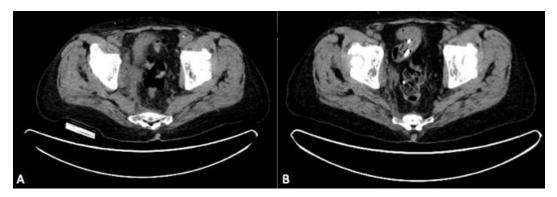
A: Initial PET/CT showing the pelvic sidewall mass measuring approximately 6.5 cm B: Restaging PET/CT showing a significant decrease in size and SUV activity in the right pelvic sidewall mass and no evidence for new lesions
